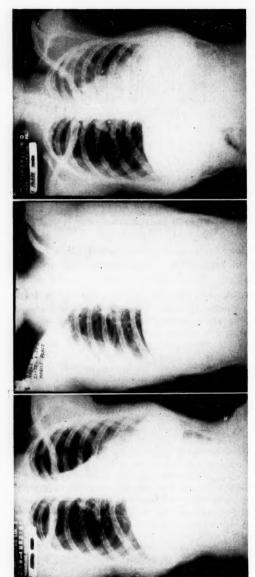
Case I. M.R., black, female, aged twenty-four. Roentgenogram taken February 18, 1948 reveals moderately advanced tuberculosis in both lung fields.
